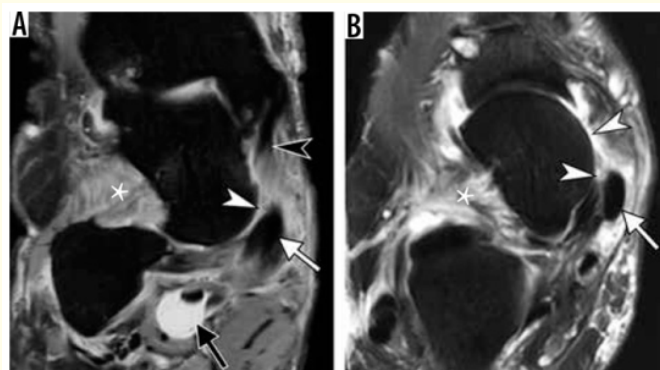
and 10B: Flat foot deformity. Coronal fat-suppressed proton-density-weighted (A) and axial T2-weighted (B) magnetic resonance images of the ankle demonstrate mildly enlarged posterior tibialis tendon (PTT) (arrow).
